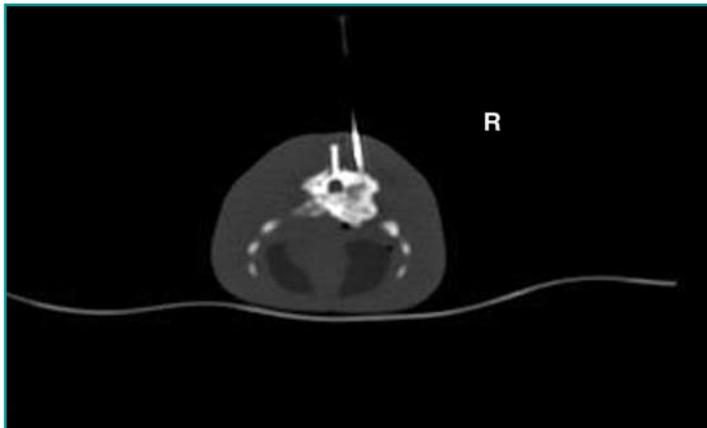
CT guided biopsy of the proliferative lesion.
